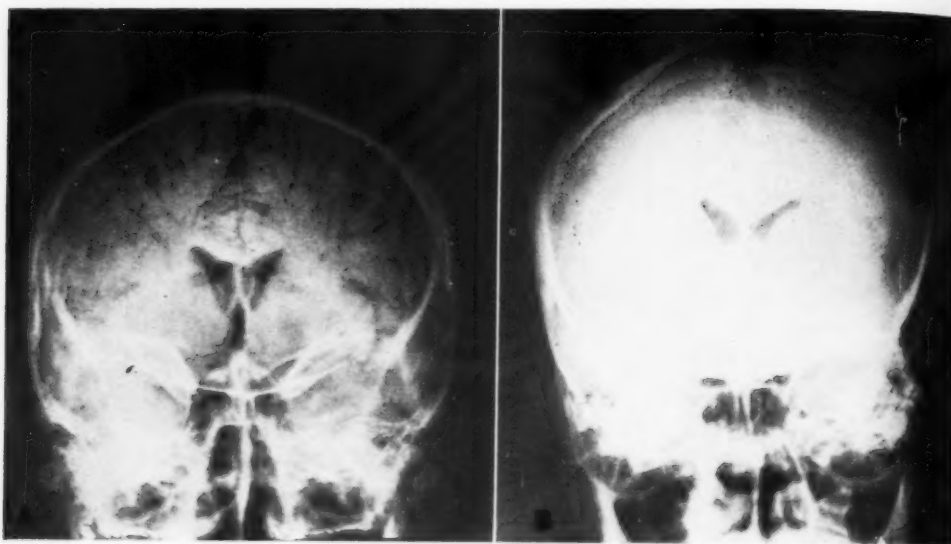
A. Immediate pneumoencephalogram, showing no subdural gas. B. Twenty-four-hour roentgenogram, showing no subdural gas. Subarachnoid gas has disappeared. Slight collapse of lateral ventricles (ventricular outline retouched).
